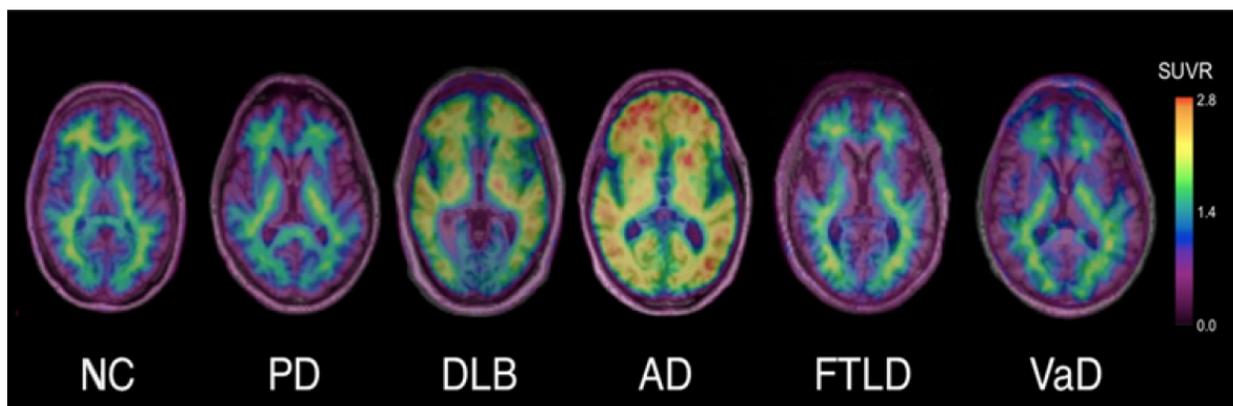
Examples of florbetaben PET transaxial images overlaid on co-registered MRI, rainbow scale (Study A42404)
